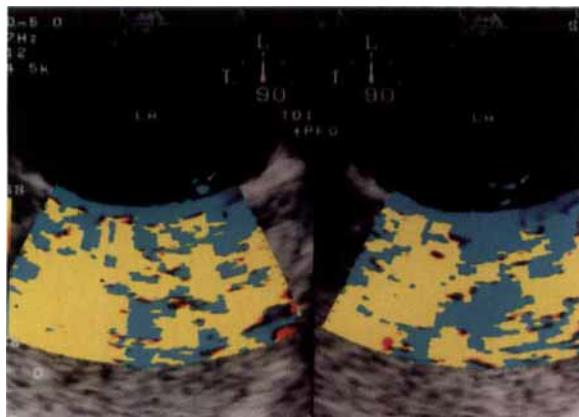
Tissue Doppler imaging (TDI) enhances peripheral saline contrast injection of a small right-to-left shunt through a patent foramen ovale (PFO). Arrows indicate the presence of microbubbles in the left atrium (LA). (Velocity range, 2.88 cm/sec.)
